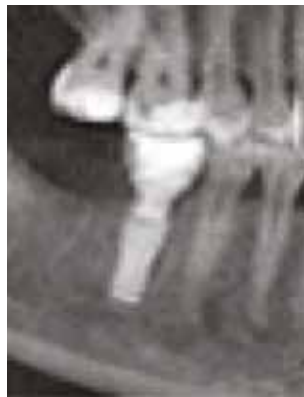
Mandibular implant with a radiolucent area on the mesial aspect (as noted on CBCT PAN view) with no clinical mobility or sensitivity reported by the patient.
